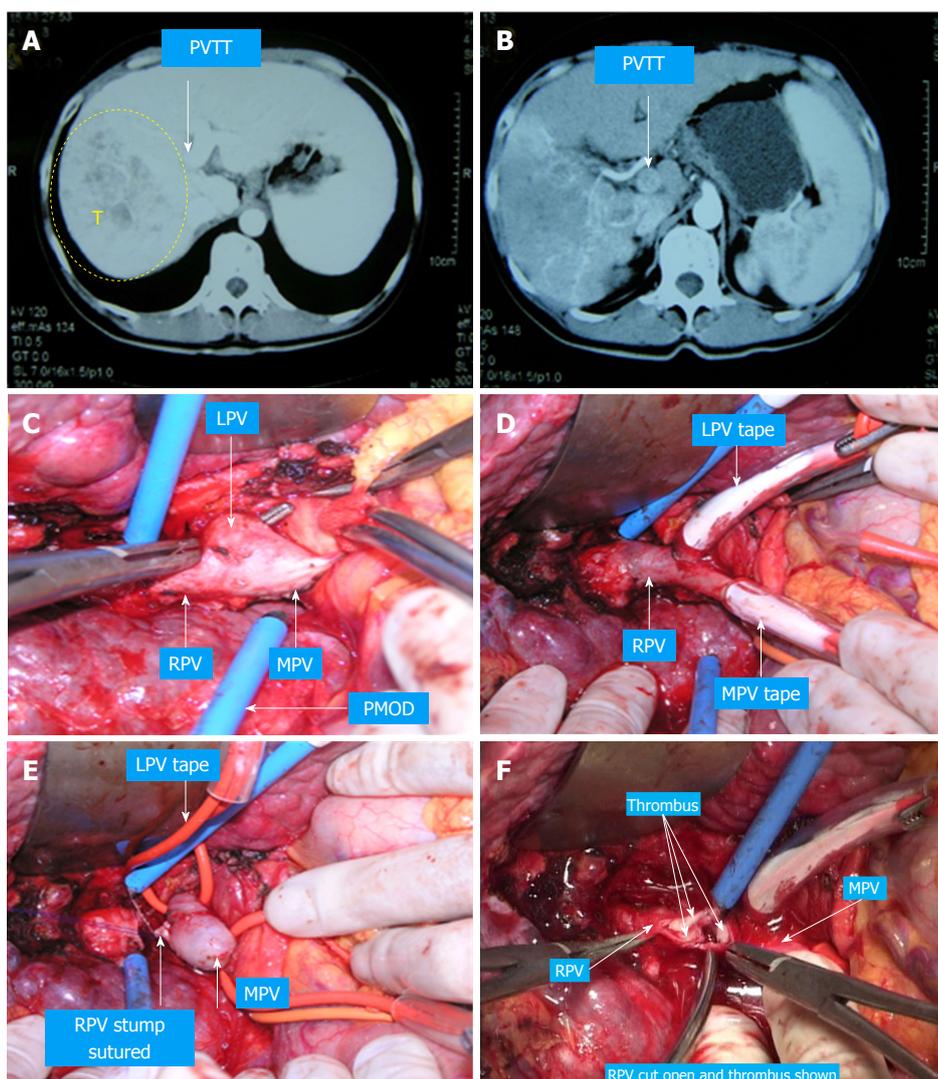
Case 2. A: The computed tomography scan showed tumor thrombus in the right portal vein (RPV) and portal vein (PV). B: Transcatheter arterial chemoembolization was performed before the operation. C and D: The left portal vein (LPV), RPV and PV were clearly revealed by dissecting the hepatic artery-hepatic duct flap. E: The LPV and PV were taped. F: Tumor thrombus in the RPV and PV was extracted. G: The tumor thrombus in the LPV was extracted, and the RPV stump was closed. H: Live transection was performed by the anterior approach. PV: Portal vein; PVTT: Portal vein tumor thrombus; RPV: Right portal vein; LPV: Left portal vein; MPV: Main portal vein; HA-HD: Hepatic artery-hepatic duct.
